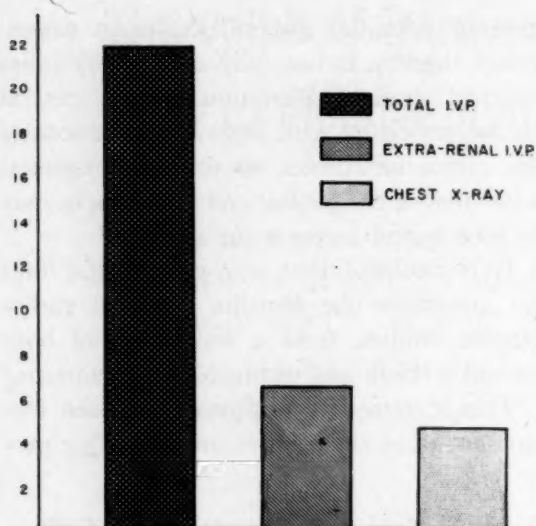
Comparative effectiveness of routine intravenous pyelography and chest radiography in terms of percentage yield of information.
